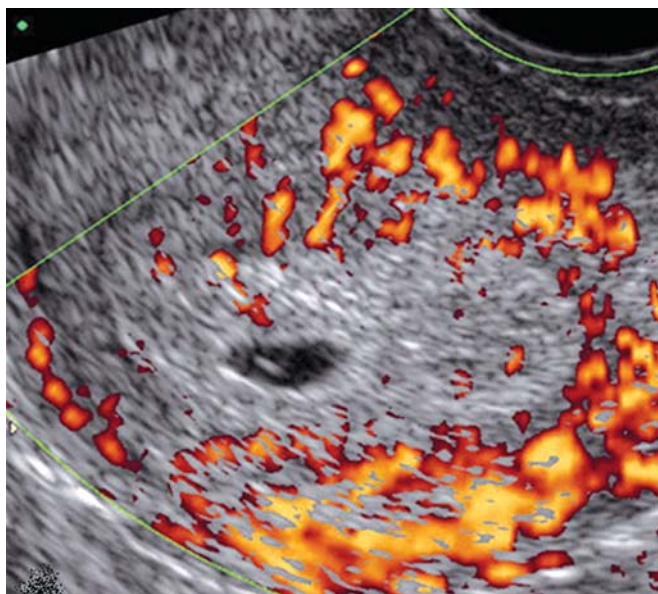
Image recorded by 2D power Doppler sonography showing increased blood flow that surrounds the gestational sac as a direct consequence of the spiral arteries dilation
